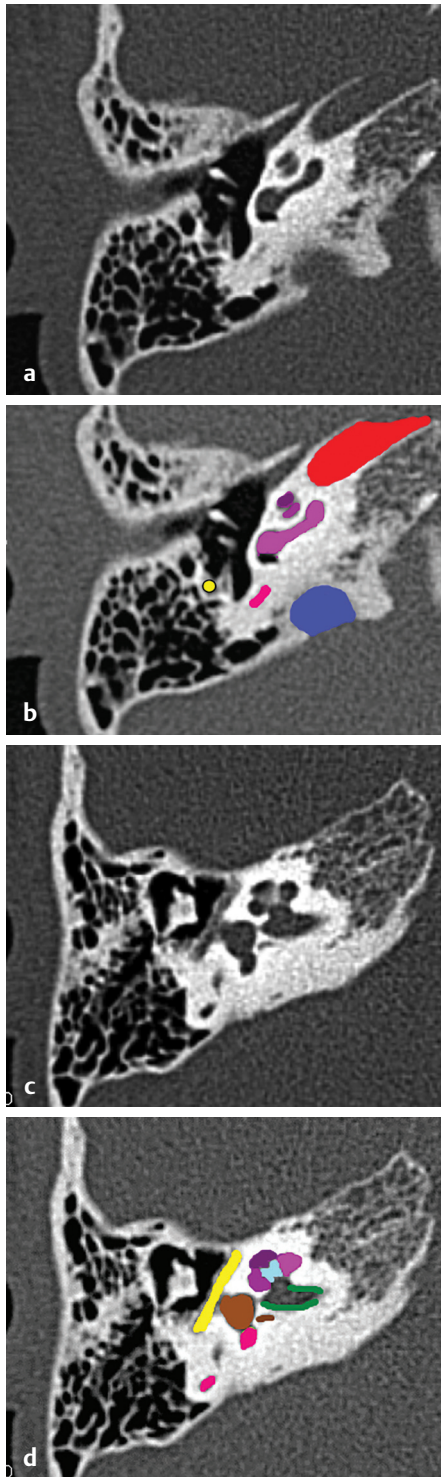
HRCT temporal bone, axial section, bone window show (a, b, c, d) (light blue) modiolus, (purple) apical turn of cochlea, (dark pink) middle turn of cochlea, (pink) posterior SCC, (yellow) tympanic segment of facial nerve, (brown) vestibule and singular canal, (light green) lateral SCC, (dark green) IAC, (Continued)
